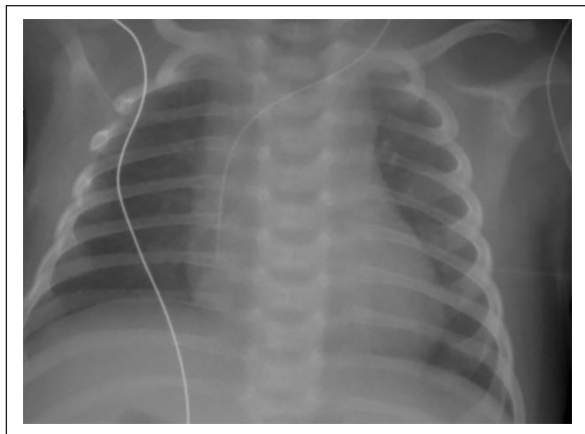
Chest X-ray tip position control.
